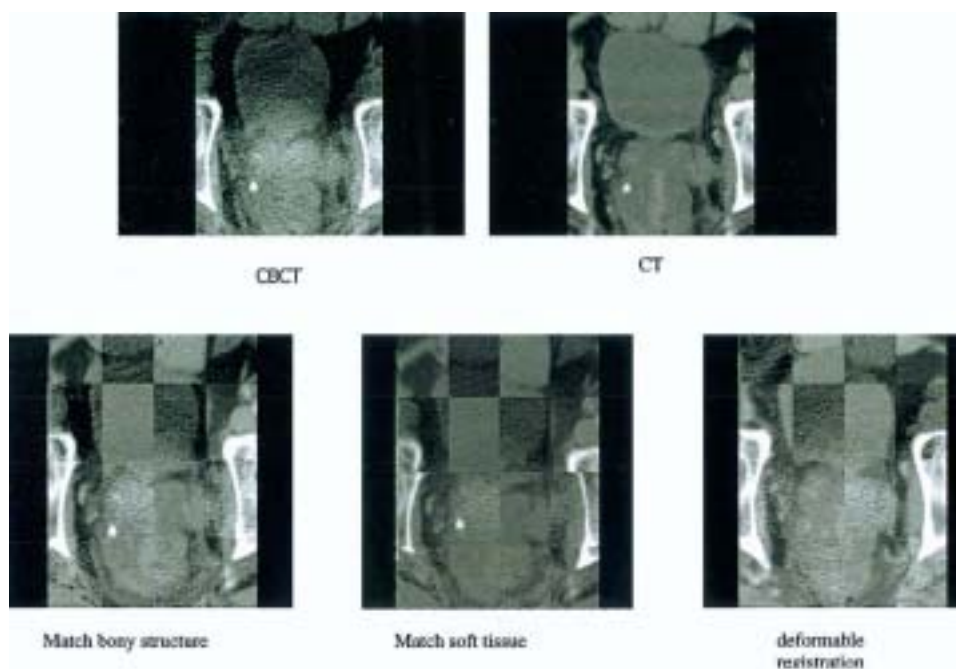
Image registration of CBCT and planning CT based on bony structure matching, soft tissue matching, and deformable registration. Different matching techniques emphasize on different aspect of the multidimensional problem.
